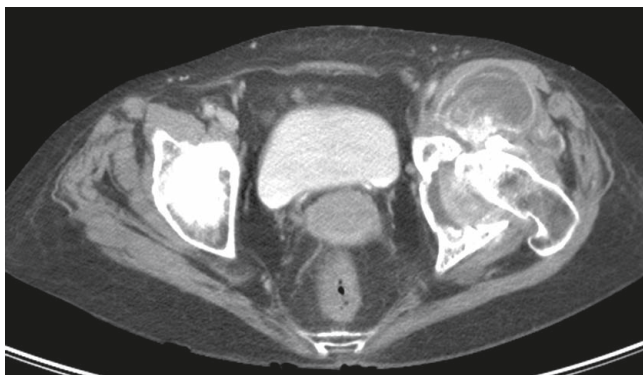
Computed tomography shows the left inguinal cyst. The connection between the cyst and the hip joint is clearly demonstrated.
